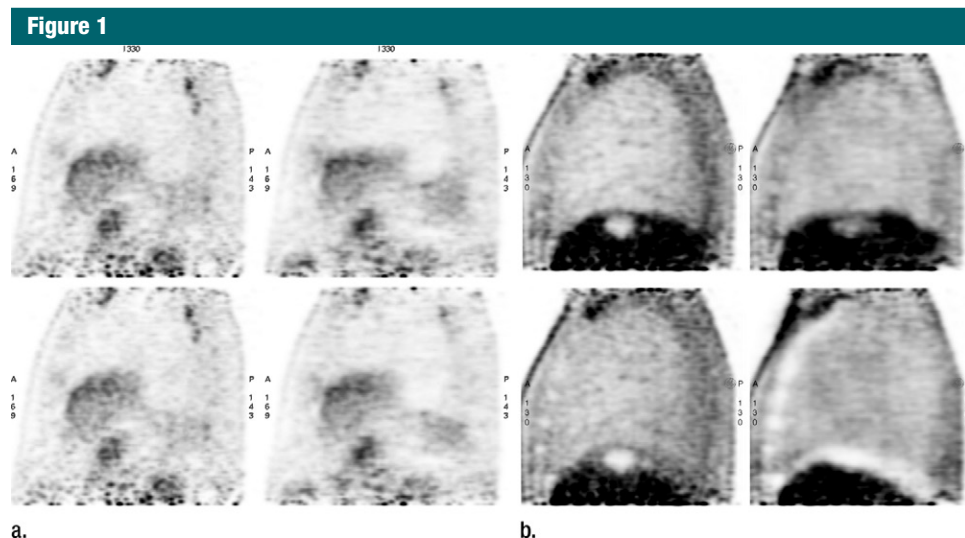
Sagittal PET images in two patients. (a) Images in patient 2 show one of the FDG-avid pleural lesions. (b) Images in patient 8 show the FDG-negative lesion in the apex of the liver. The top row shows reconstructions that use free-breathing attenuation correction data, the bottom row shows reconstructions that use breath-hold attenuation correction data (inspiratory breath hold). The views on the left column were reconstructed by using TOF information and the views on the right were reconstructed without TOF information.
